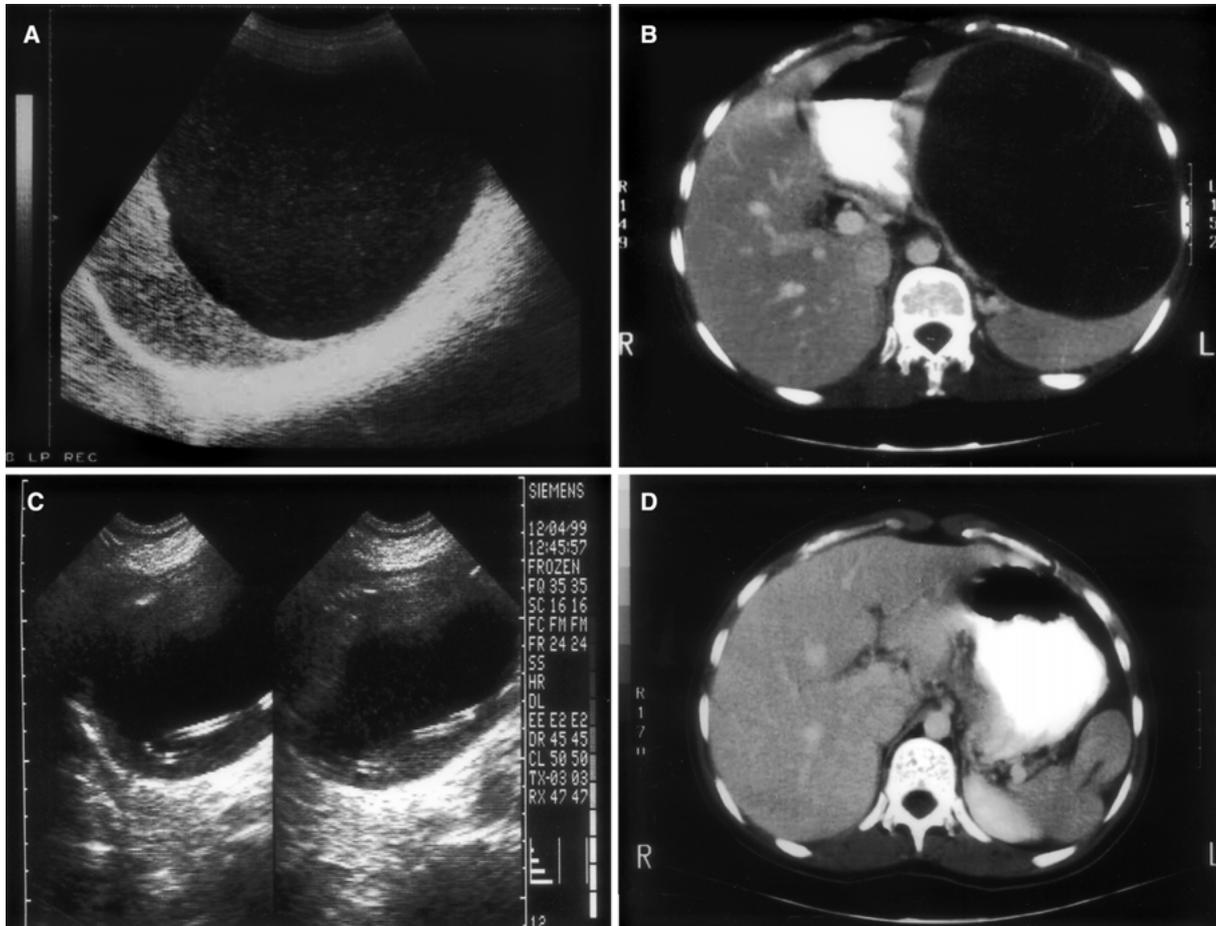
The patient (# 1) with a giant nonparasitic “true” splenic cyst. A Longitudinal US scan shows well-marginated and purely anechogenic cystic lesion of the spleen with floating small echo enhancements. B Axial contrast-enhanced CT image shows a large, well-defined, homogenous, low-attenuating splenic mass compressing the normal splenic tissue; note the displacement of stomach and compression of left hepatic lobe. C Axial US scans obtained
